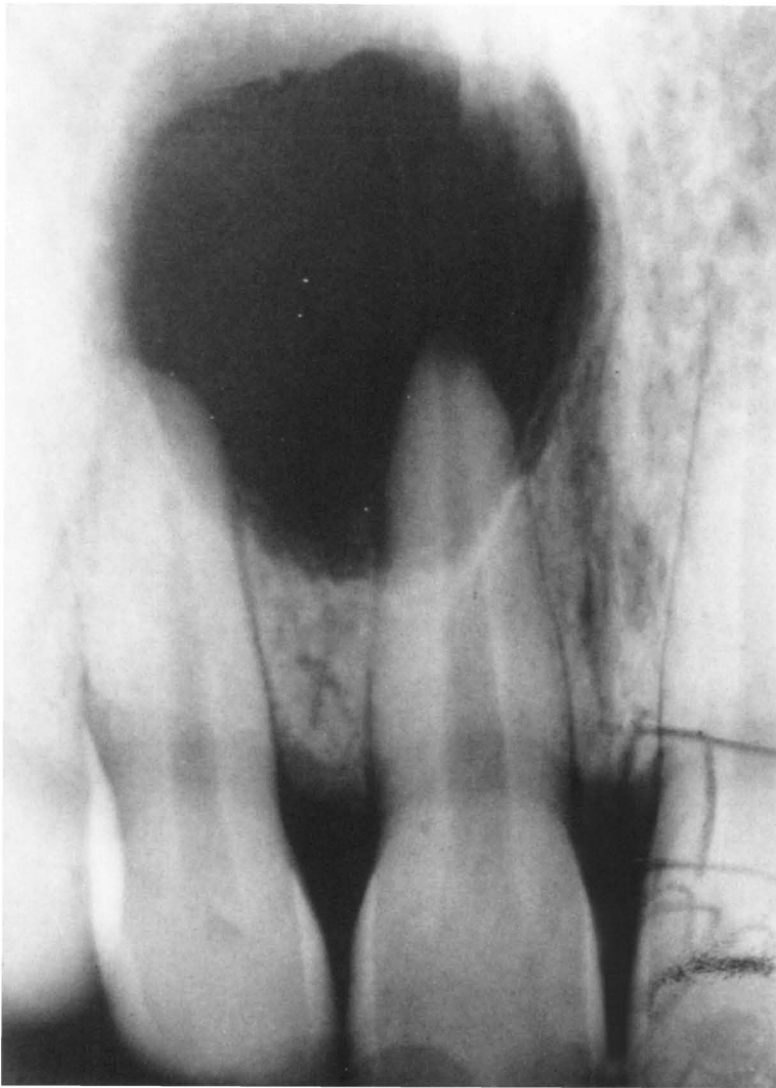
A periapical radiograph of a periapically positioned radicular cyst associated with a maxillary central incisor with necrotic pulp.
